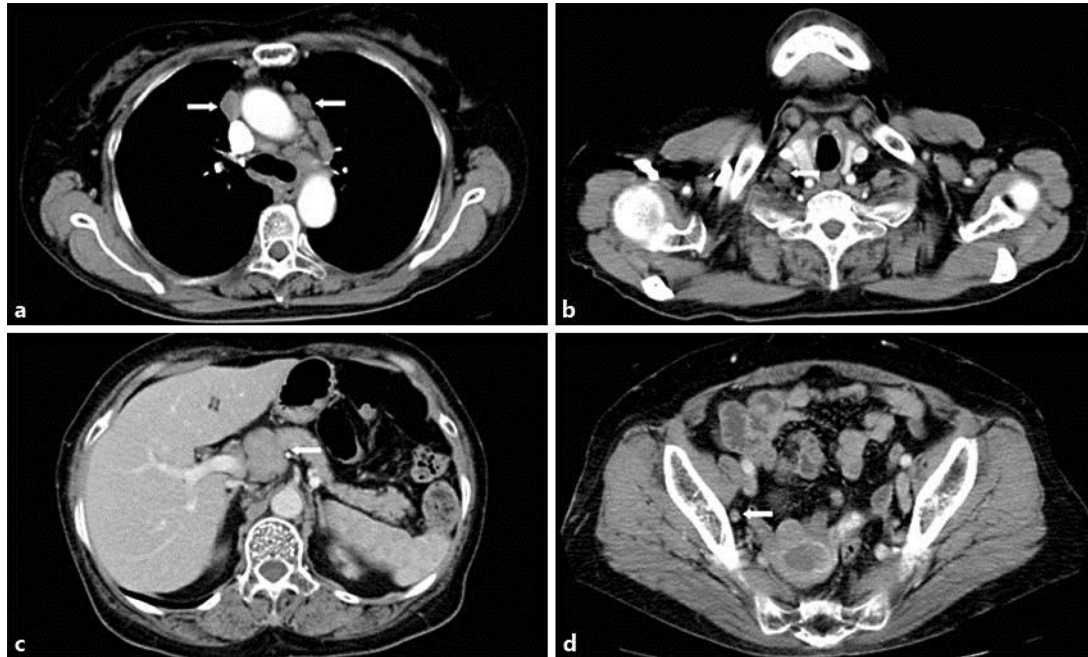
CT findings of swollen lymph nodes. a Swelling of bilateral hilar lymph nodes (arrows). b Swelling of a right supraclavicular lymph node (arrow). c Swelling of a pancreatic head lymph node (arrow). d Swelling of a right pelvic lymph node (arrow).
